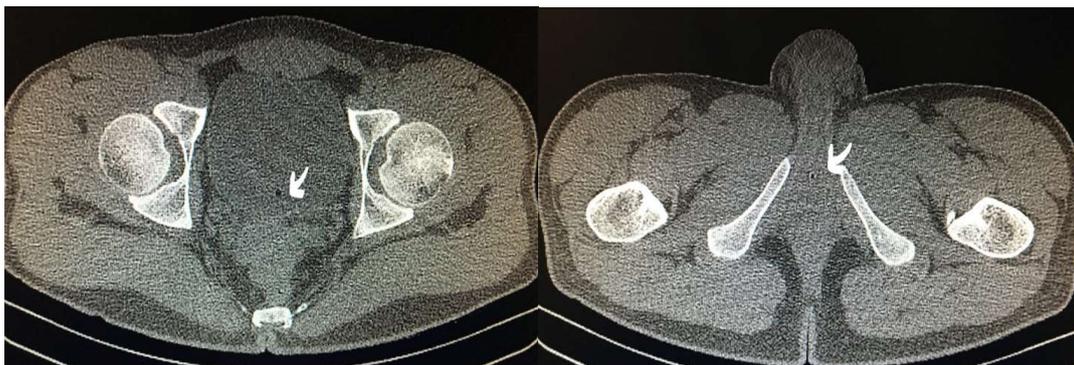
Pelvic computed tomography revealed non-specific findings like circular structures in air density (white arrows).
